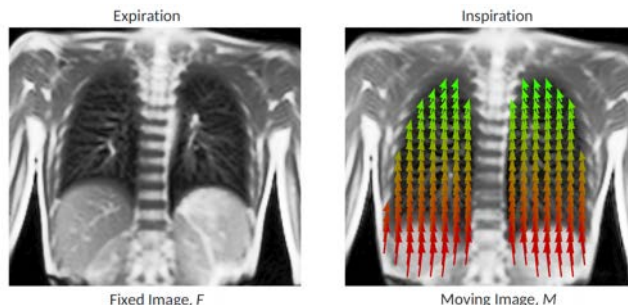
MR images of the lung during expiration and inspiration. Overlaid vector field shows the lung motion between inspiration and expiration (Picture: R. Sandkühler).
